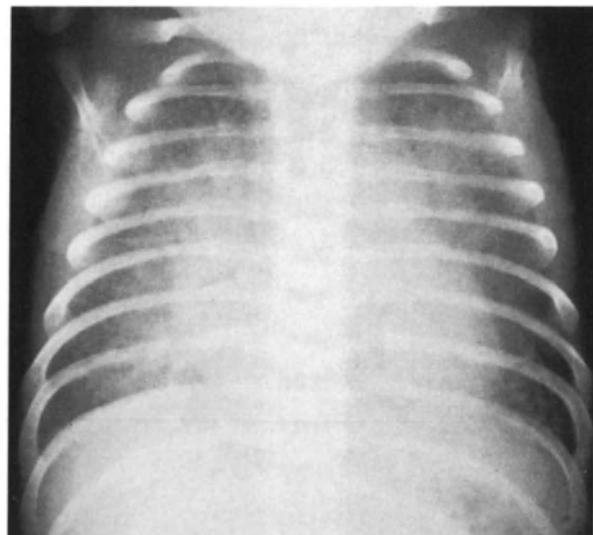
Chest radiograph from a patient with L-loop transposition of the great arteries ('corrected transposition'). The left heart border has a long rounded curve formed by the abnormally positioned aorta. In some patients with this condition this feature is not obvious and the appearances may be indistinguishable from normal.
